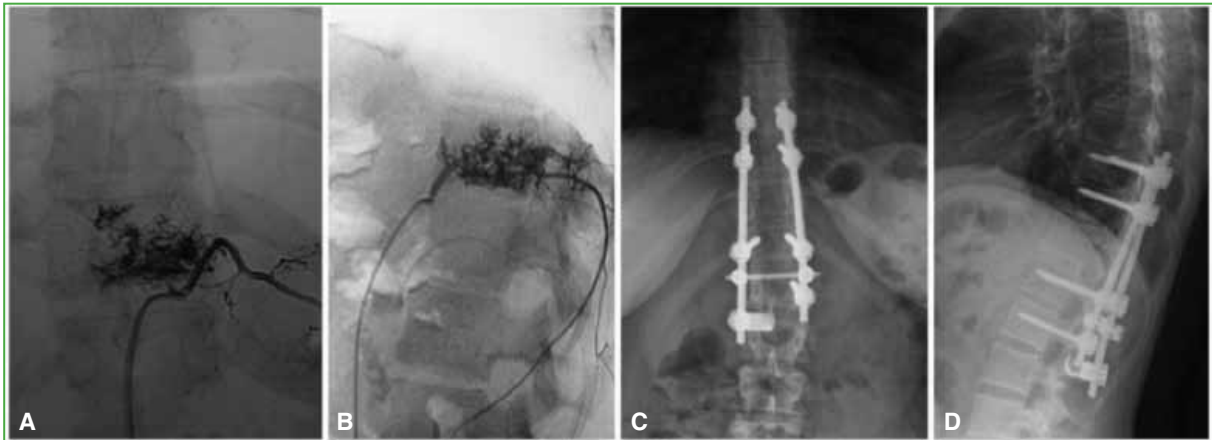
Case 2. A 23-year-old woman. Anteroposterior (A) and lateral (B) fluoroscopy images of the dorsal spine lesion at the T11 level during the selective arterial embolization procedure of the nutrient artery. Anteroposterior (C) and lateral (D) radiographs of the thoracic spine at 5 years of follow-up. Decompression and dorsolumbar arthrodesis from T9 to L1 are visualized.
